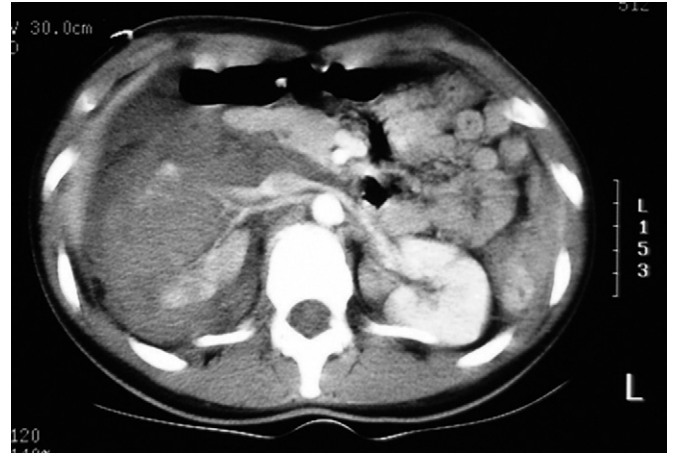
CT scan of patient with a grade IV renal laceration and vascular injury.
